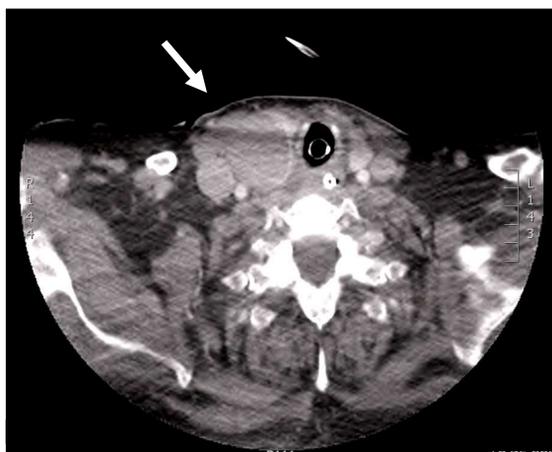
Cervical CT scan
